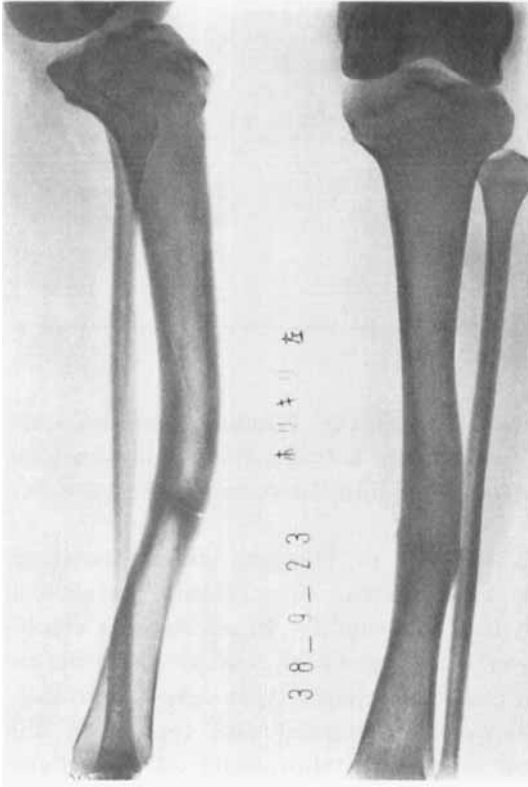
Roentgenogram of the left leg. Case 2. A transverse fracture of mid-tibia in the healing phase was seen with spindle shaped thickening and anterior bowing.
